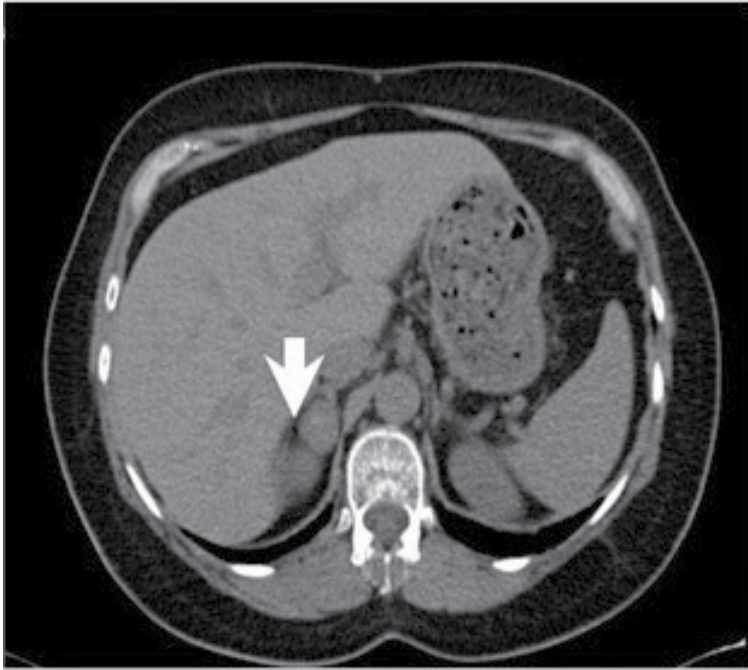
Axial CT imaging of a right adrenal heterogeneous mass measuring 34 hounsfield units on noncontrast phase. On enhanced and delayed series, the mass demonstrated relatively little washout and CT features are consistent for a pheochromocytoma.
